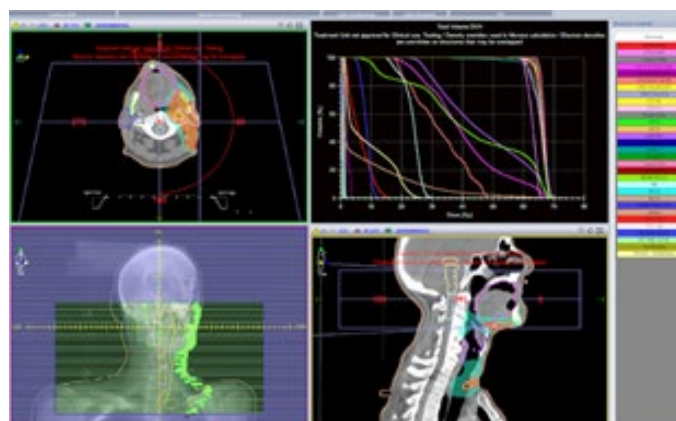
Computed tomography scan showing the target volumes: PTV-HR high risk in Red, PTH-IR intermediate risk in White. Volumetric modulated arc therapy was delivered to the region of high risk, to doses of 66 Gy.
